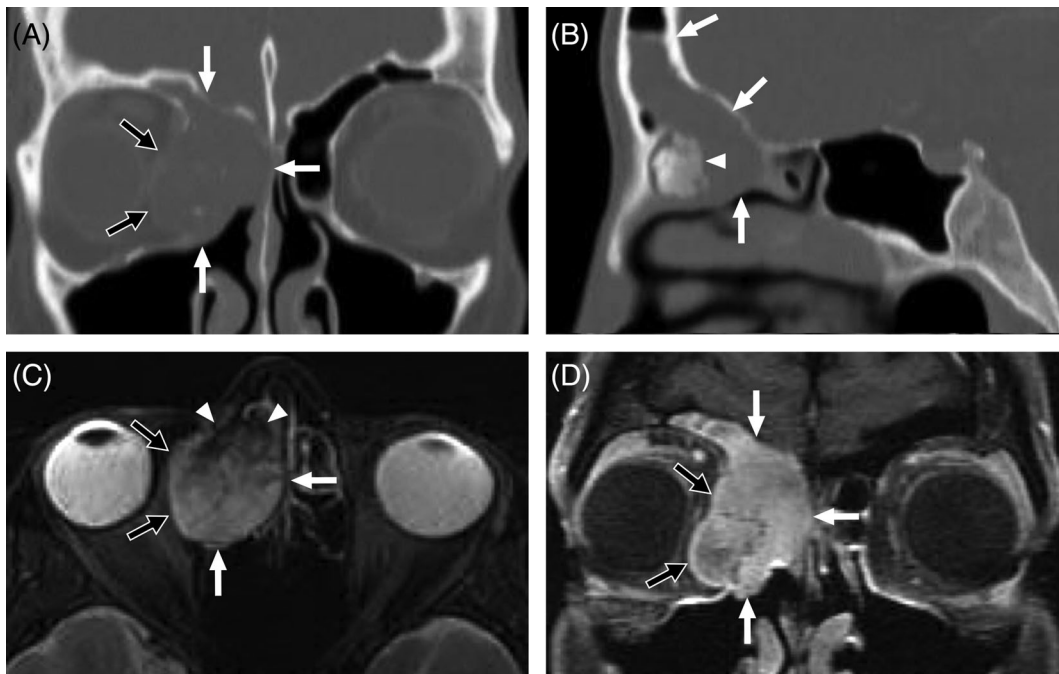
Imaging features of BSS in a 58 year-old woman. (A) Coronal contrast-enhanced CT. (B) Sagittal contrast-enhanced CT. (C) Axial T2-weighted MRI with fat saturation. (D) Coronal contrast-enhanced T1-weighted MRI with fat saturation. A large heterogeneously enhancing mass (white arrows) centered in the right anterior ethmoid air cells and upper nasal cavity extends from the medial right orbit to the nasal septum and also protrudes superiorly through the right frontal recess. The mass has eroded the right lamina papyracea and invades into the orbit (black arrows) but is still contained by periorbita. A conglomerate area of hyperostosis in present just posterior to the ager nasi (white arrowheads). In addition to T2 hypointensity related to this hyperostosis, the remainder of the mass more posteriorly is heterogeneous on T2-weighted MRI demonstrating mixed isointensity and hyperintensity relative to cerebral gray matter. The anterior skull base is intact, and no intracranial extension is present.
